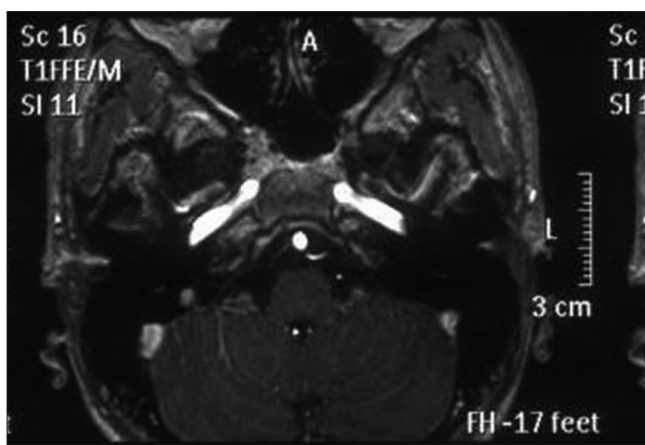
Magnetic resonance imaging of the brain showing no abnormalities
